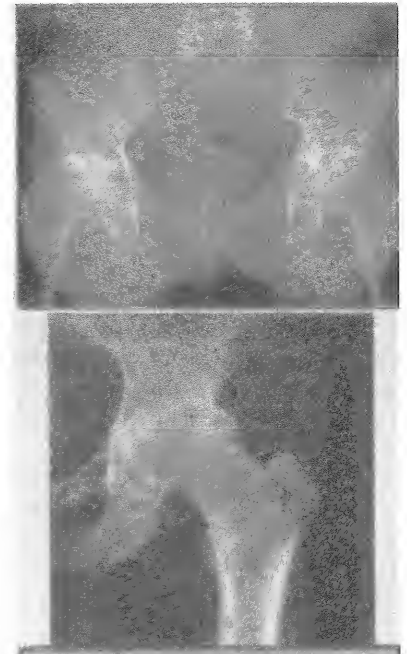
X-ray showing hip osteoarthritis with narrowing of joint space and subarticular sclerosis
